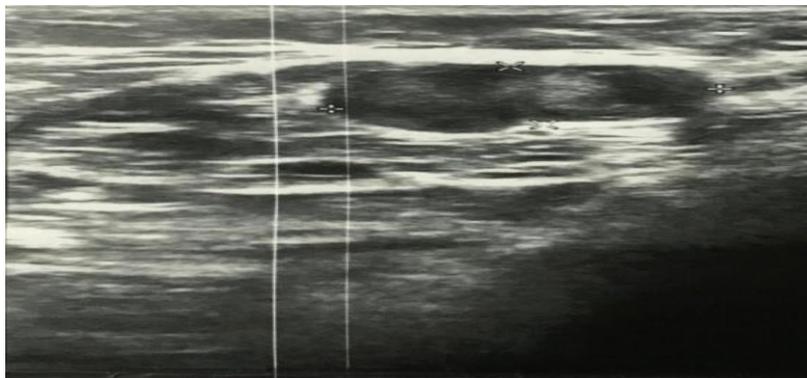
Ultrasound image of right breast, retroareolar region demonstrating 3 cm heterogeneous mass
